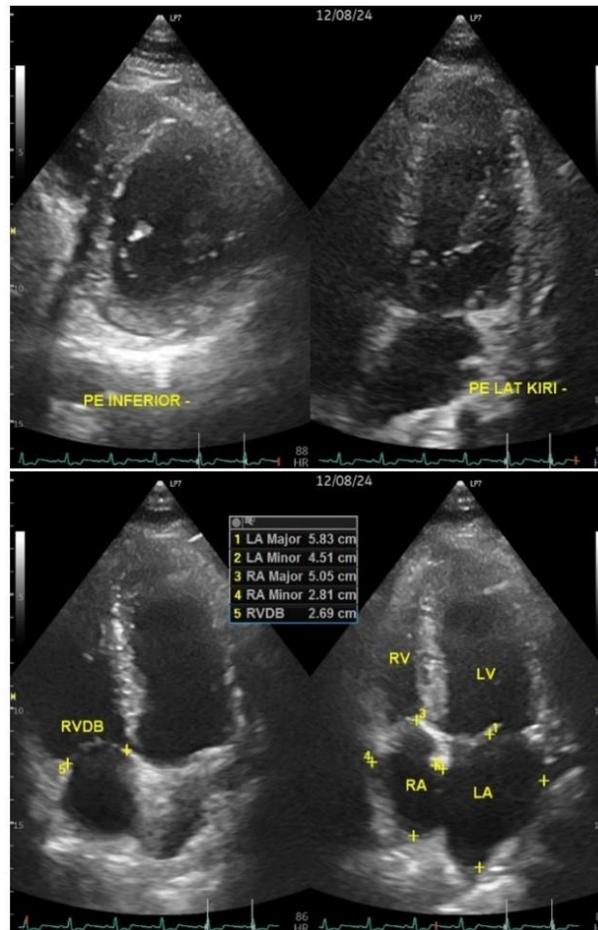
Evaluation of echocardiography showing complete resolution of the pericardial effusion following the administration of prednisone and sulfasalazine
